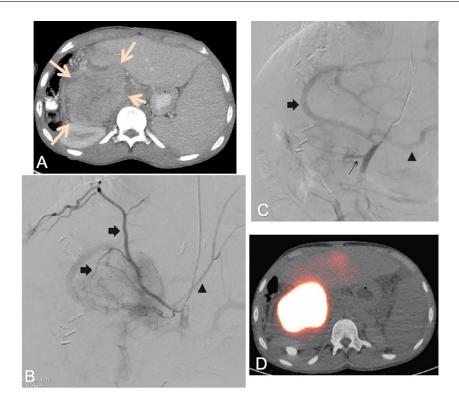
A 16-year-old male with fibrolamellar hepatocellular carcinoma who presented with loss of appetite. (a) Axial contrast enhanced computed tomography of the abdomen showing 10.0 x 7.5 x 14.0 cm (Volume: 440 cm³) subhepatic solitary fibrolamellar hepatocellular carcinoma metastasis (arrows). (b) Transradial inferior phrenic digital subtraction arteriogram during the planning procedure demonstrating tumor blush along the superior aspect of the mass. Distal diaphragmatic (block arrows) and left inferior phrenic artery (triangle) branches are noted. (c) Transradial celiaco-mesenteric trunk digital subtraction arteriography demonstrating a large tumor branch arising from the superior mesenteric artery (skinny arrow). The common hepatic (block arrow) and splenic artery (triangle) are noted. (d) Pre-TARE Tc-99m MAA SPECT-CT showing tracer uptake predominantly within the mass localized to the right lobe of the liver with a faint focus of uptake in the left lobe of the liver.
